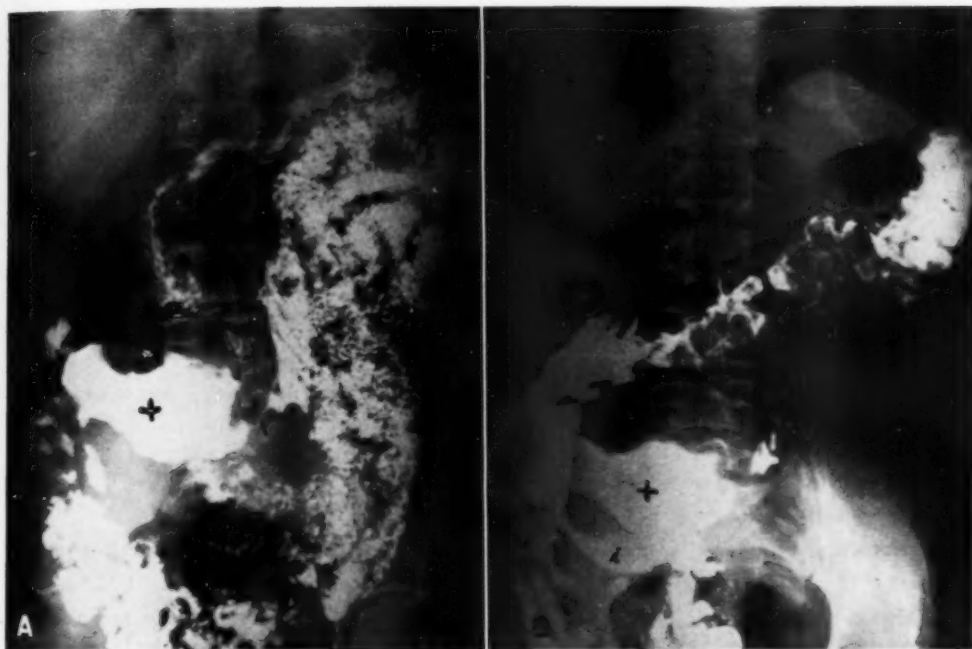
Case II. A. Roentgenogram showing irregular barium-filled cavity (+) and fistulous communication (arrows) with the jejunum, as well as displacement of barium-filled small bowel loops. B. Four-hour film demonstrating retention of barium in necrotic portion of tumor (+) and compression changes at the terminal ileum (i).
